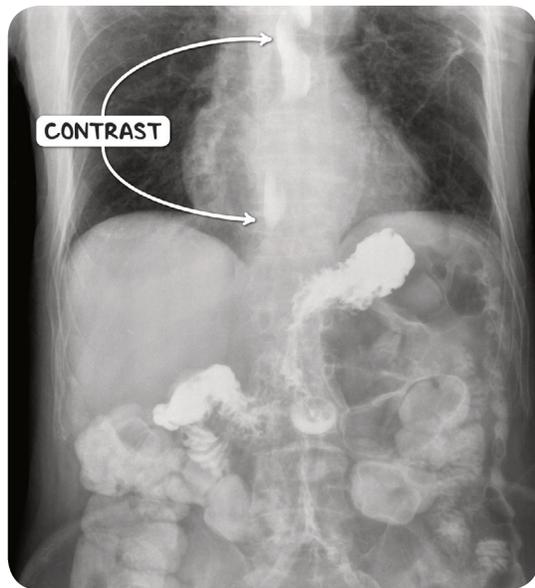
A contrast X-ray demonstrating gastroesophageal reflux. The contrast medium was injected percutaneously into the stomach and has migrated into the esophagus.
